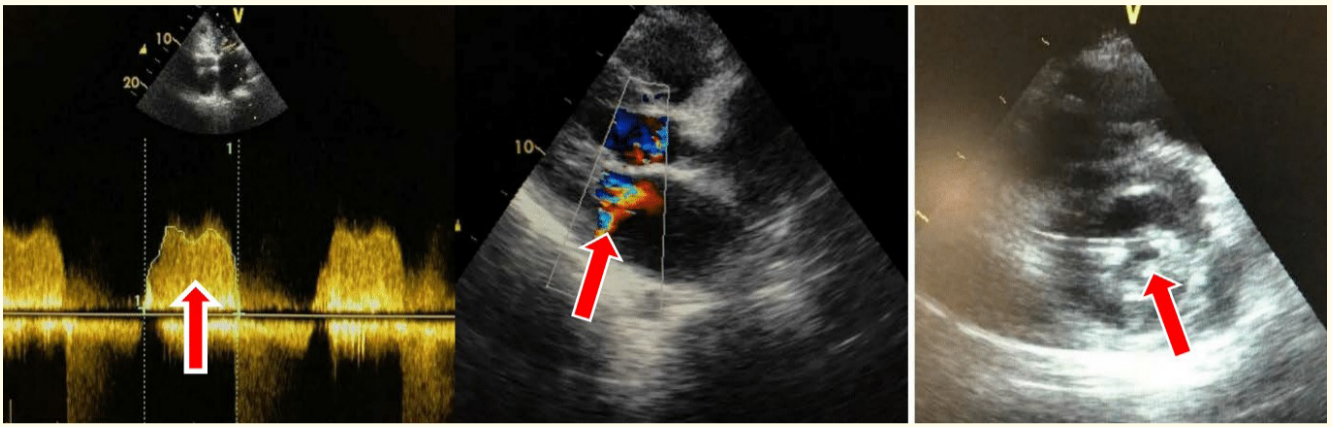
TTE apical 4 chamber, parasternal long and short axis views showing severe mitral stenosis ($MVA = 0.6 \text{ cm}^2$, $MDG = 13 \text{ mmHg}$) and moderate eccentric posterior regurgitation.
